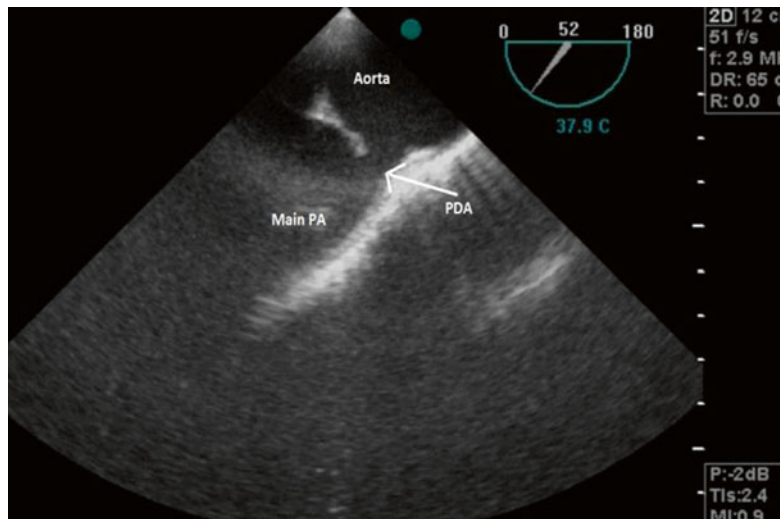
Large PDA in transesophageal echocardiography study. *PDA* patent ductus arteriosus
